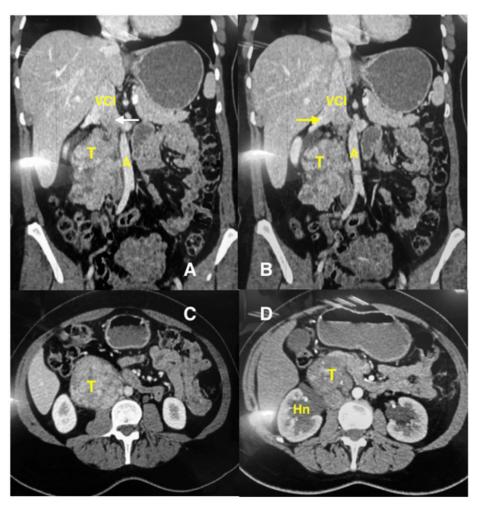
38 year old female with leiomyosarcoma arising from the Inferior Vena Cava. A - B: Multiplanar coronal CT plane images 5mm and 64 detectors. (A) Arterial phase image that shows the relation of the neoplasm with the IVC which is indistinguible in all its length due to the contact with tumor (T), is only visible the superior portion (IVC) and (white arrow). (B) Relation of the IVC leiomyosarcoma (T) and its relation with aorta (A) the neoplasm extents until the emergence of right kidney vein (black arrow). C - D: Multiplanar CT axial plane. (C) A large retroperitoneal neoplasm adjacent to aorta growing from IVC (T) The IVC is not perceptible. (D) Neoplasm infiltrate elements from the hilum causing right hydronephrosis. (Hn).
